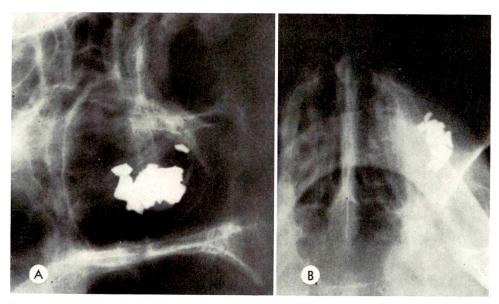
Case 3 reported by Kligerman *et al.*<sup>7</sup> (A and B) Radiopaque mass in left antrum composed of an aggregate of numerous particles of metallic density. Note variation in size and shape of individual particles and jagged contours. (Previously unpublished roentgenograms.)
